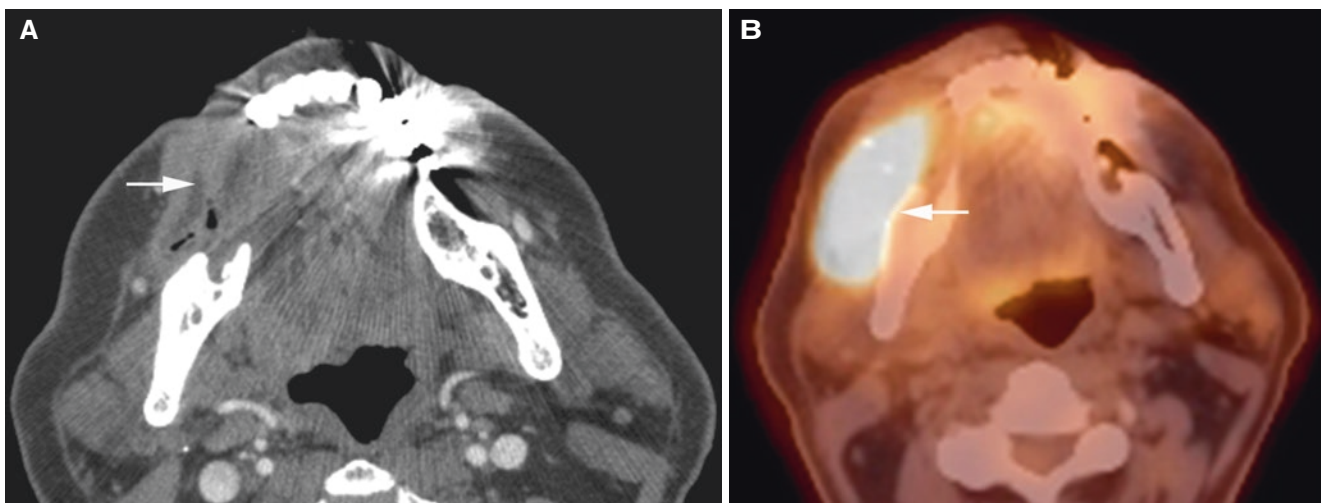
B-cell lymphoma, mandible; 53-year-old male with right-sided neck mass. (A) Contrast-enhanced axial CT image shows destruction in the mandible (*arrow*). (B) Axial PET-CT image shows intense hypermetabolic activity in tumor (*arrow*)
